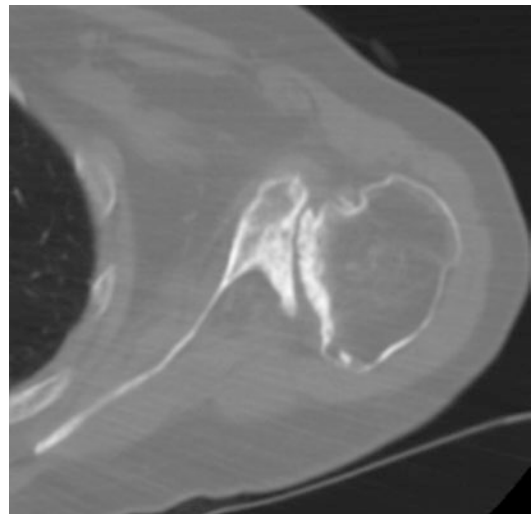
Axial CT scan of patient with a Walch B2 glenoid
